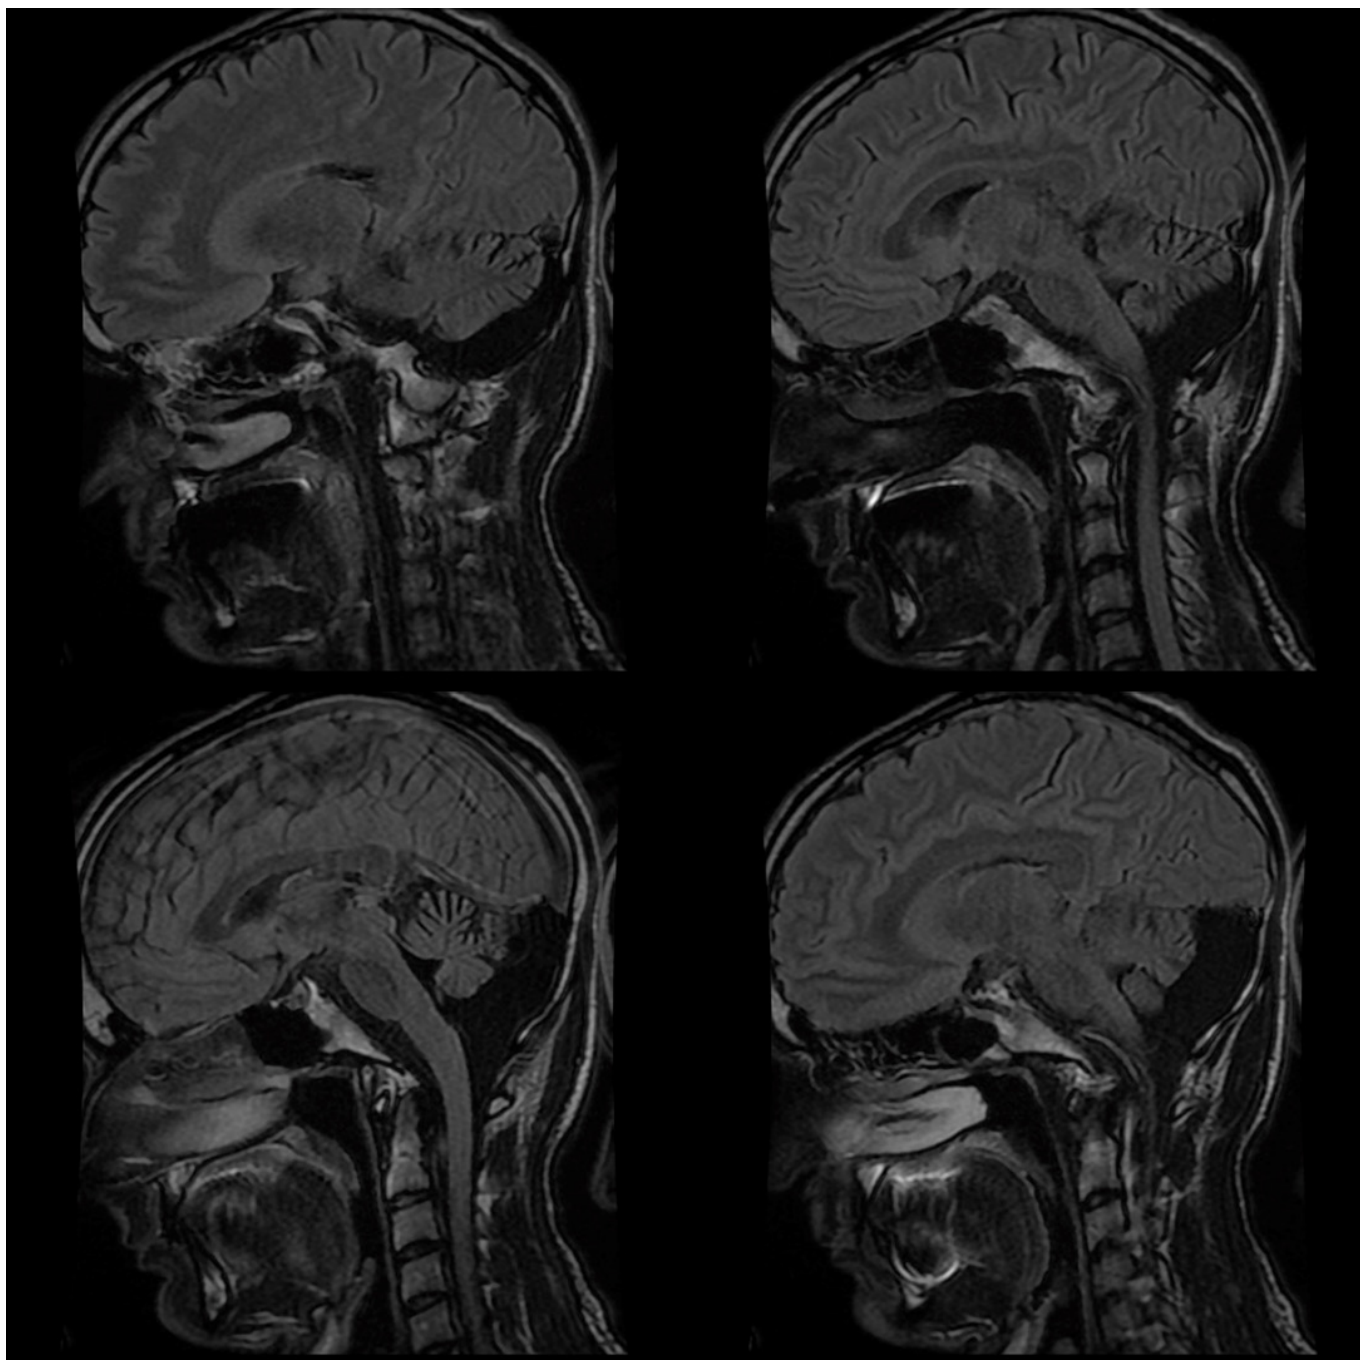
Sagittal T2 FLAIR weighted cerebral MRI revealing severe cerebellar atrophy
